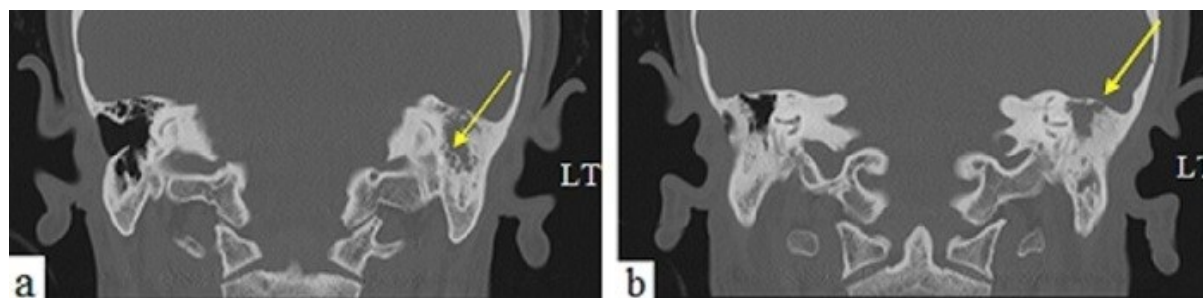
Multidetector computed tomography findings of otomastoiditis. After being treated with a long-term antifungal agent, the second follow-up of the patient was temporal bone computed tomography. Opacification of the left mastoid air cells seems to suggest mastoiditis. There is also opacification in the LT middle ear cavity in favor of infectious processes (arrow) (a-b), suggesting evidence of otomastoiditis in the LT side.
